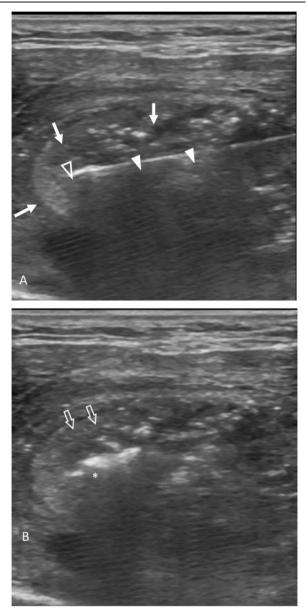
Sequential transverse ultrasound-guided image of the right lobe of thyroid during RFA via trans-isthmic approach. (A) RFA needle (white arrowheads) in situ. Active tip (open arrowhead) and thyroid nodule (arrows). (B) Echogenic change (open arrows) around the active tip represents thermocoagulation. Note the echogenic change that obscures posterior visualization (asterisk).
